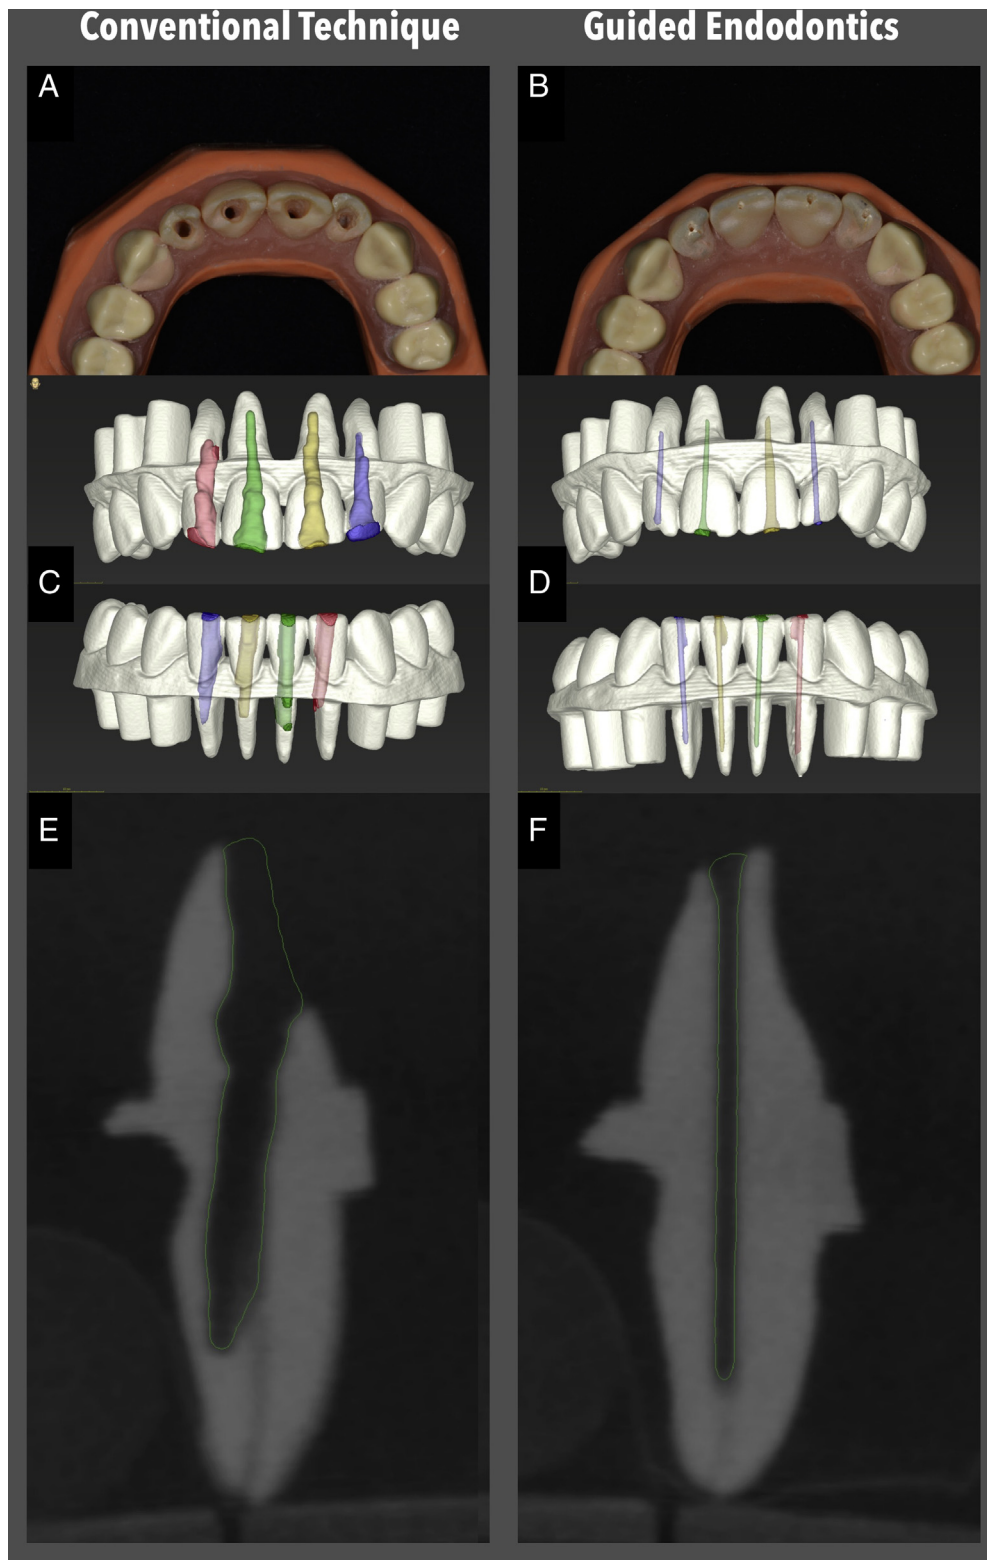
A comparison of the (*left column*) conventional technique and (*right column*) guided endodontics. (*A and B*) Examples of upper jaw models after access cavity preparation, (*C and D*) visualization of access cavities, and (*E and F*) the sagittal plane of a postoperative CBCT scan showing a lower incisor.
